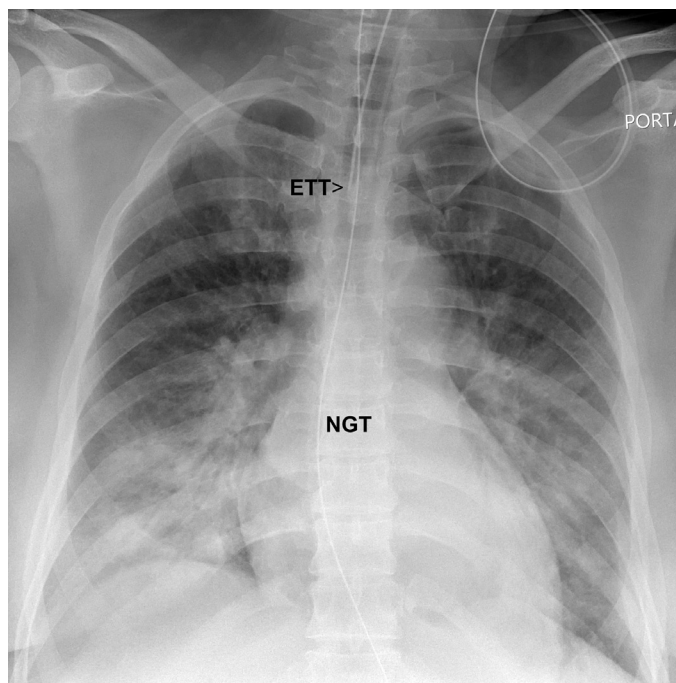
■ Anteroposterior (AP) supine chest x-ray. Bilateral lower lobe patchy airspace opacities in an intubated patient are the result of aspiration pneumonia/pneumonitis. ETT, endotracheal tube; NGT, nasogastric tube.
